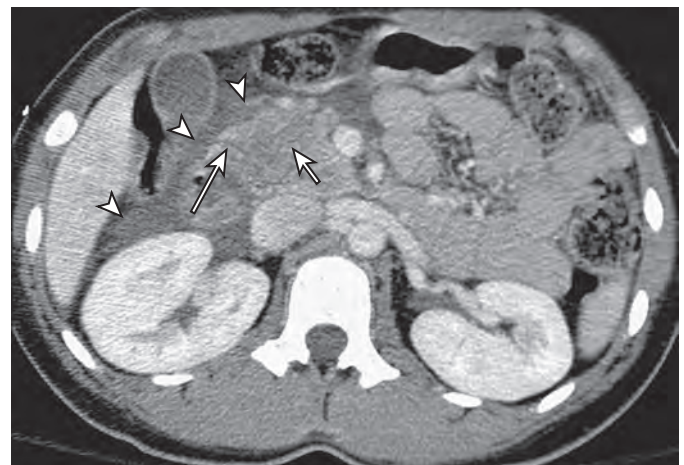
CT findings in pancreatic contusion. Axial MDCT scan of a 44-year-old woman involved in a motor vehicle accident shows a contusion of the pancreatic head (short arrow) and a subtle laceration of the head of the pancreas (long arrow). Note the presence of fluid outlining the duodenum and portion of the pancreatic head (arrowheads).
